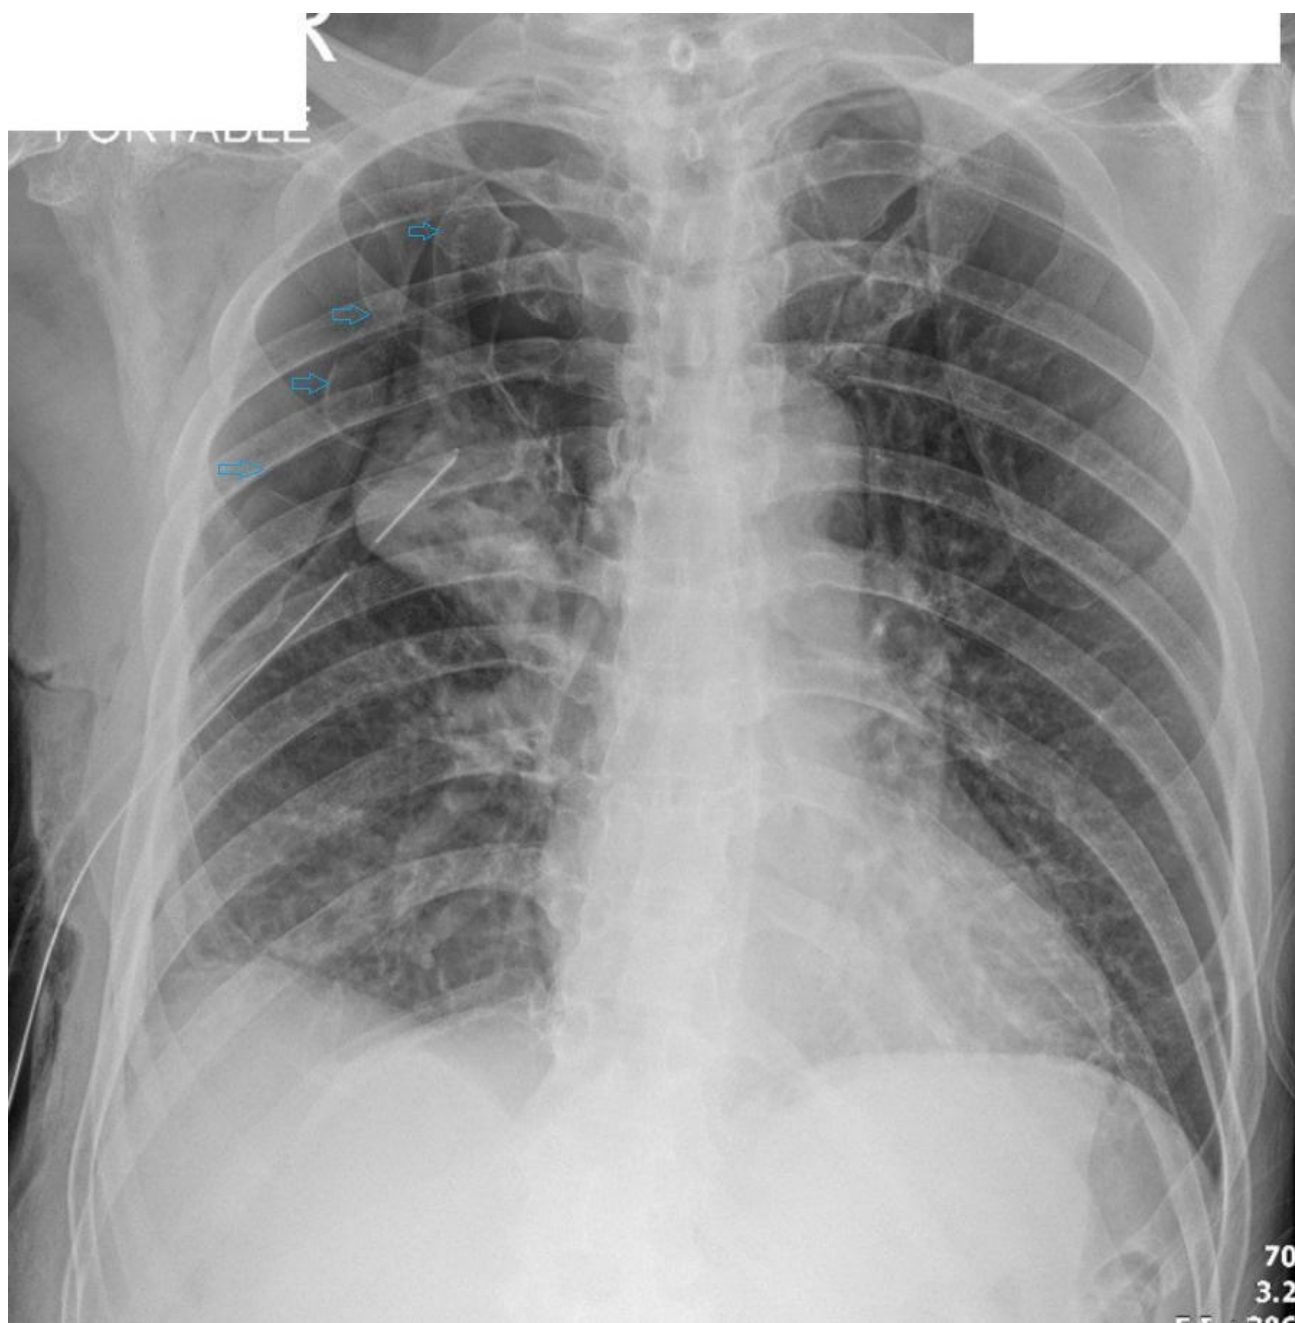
Chest radiograph showing persistent pneumothorax after autologous blood patch
